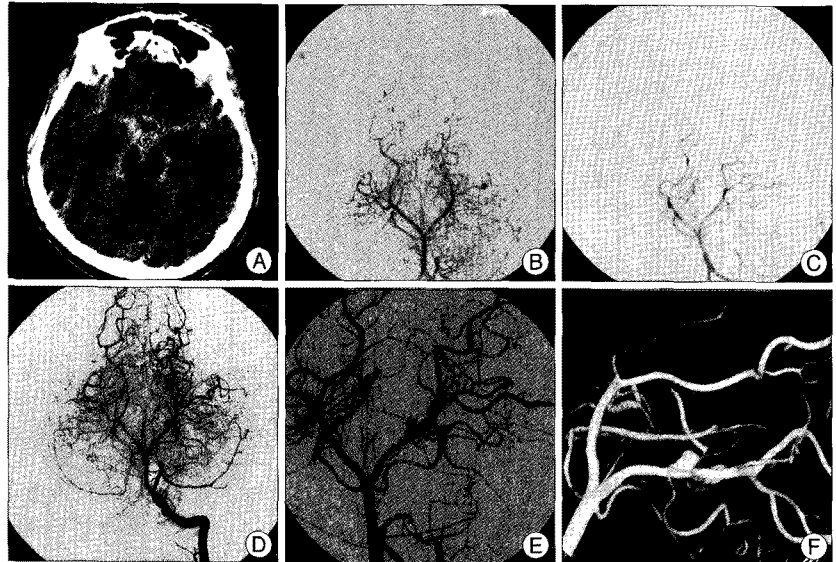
A : Brain computed tomography at presentation showing thick subarachnoid hemorrhage of basal cistern. Initial vertebral angiogram (B : Anteroposterior view, C : Oblique view) revealing no definite evidence of intracranial aneurysm. Follow-up angiogram (D, E and F : Anteroposterior view, oblique view, and 3D view, respectively) 8 days after symptom onset demonstrating dissecting aneurysm and segmental dissection of the left posterior cerebral artery at the P2 segment.
